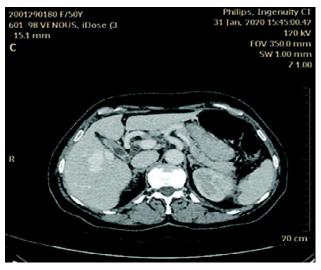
Axial post-contrast CT (venous phase) demonstrating focal conglomerate vessels in segment V s/o intrahepatic portosystemic venous shunt between right portal vein and right hepatic vein.
